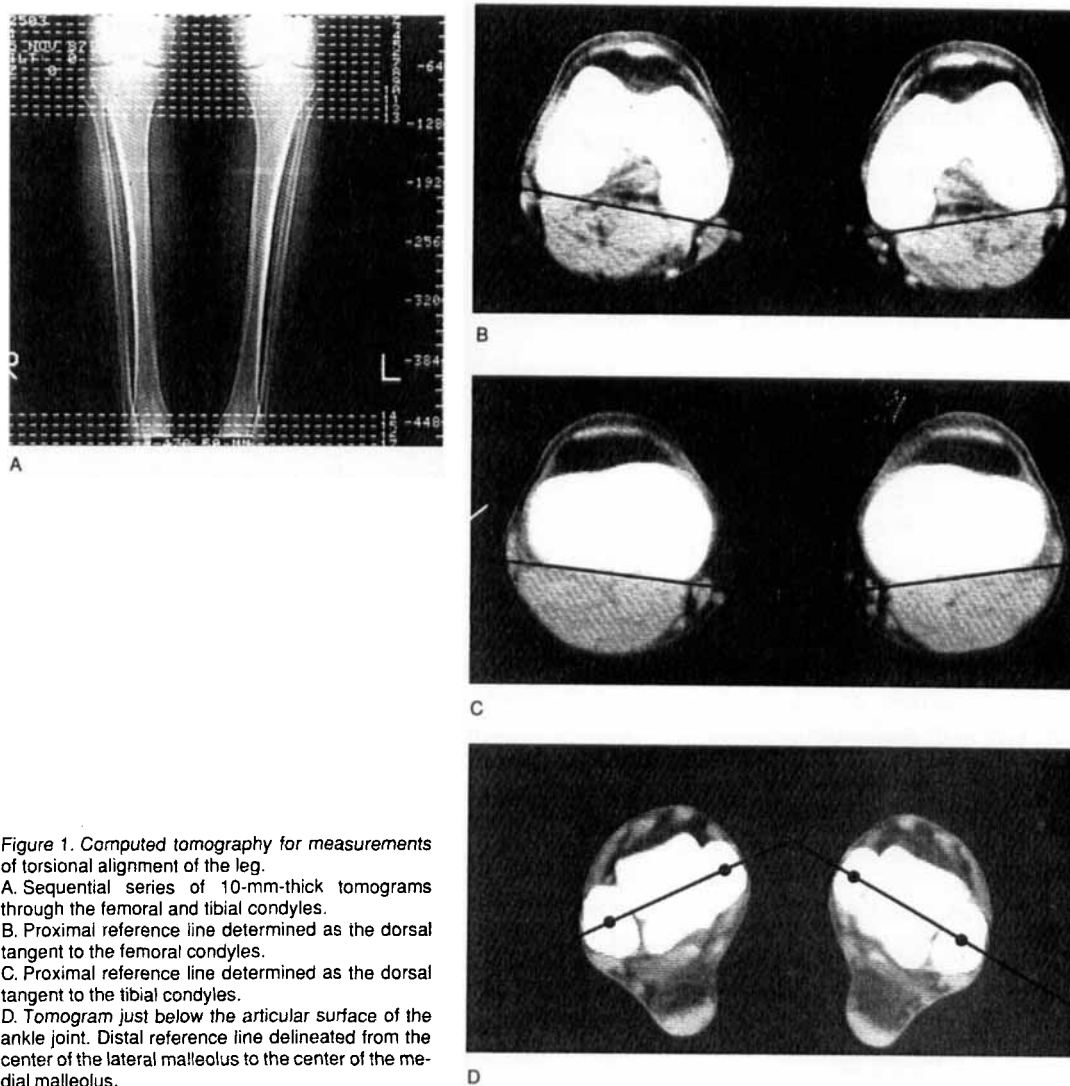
Computed tomography for measurements of torsional alignment of the leg.
